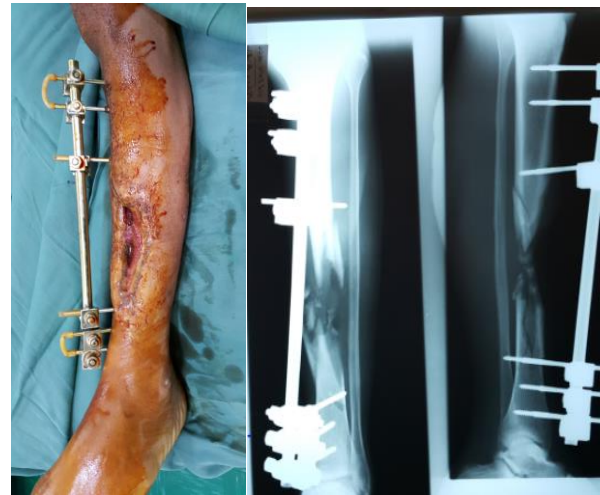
Preoperative clinical presentation and radiograph of a patient with a left tibial bone defect resulting from a gunshot injury, initially stabilized with a temporary external fixator.
